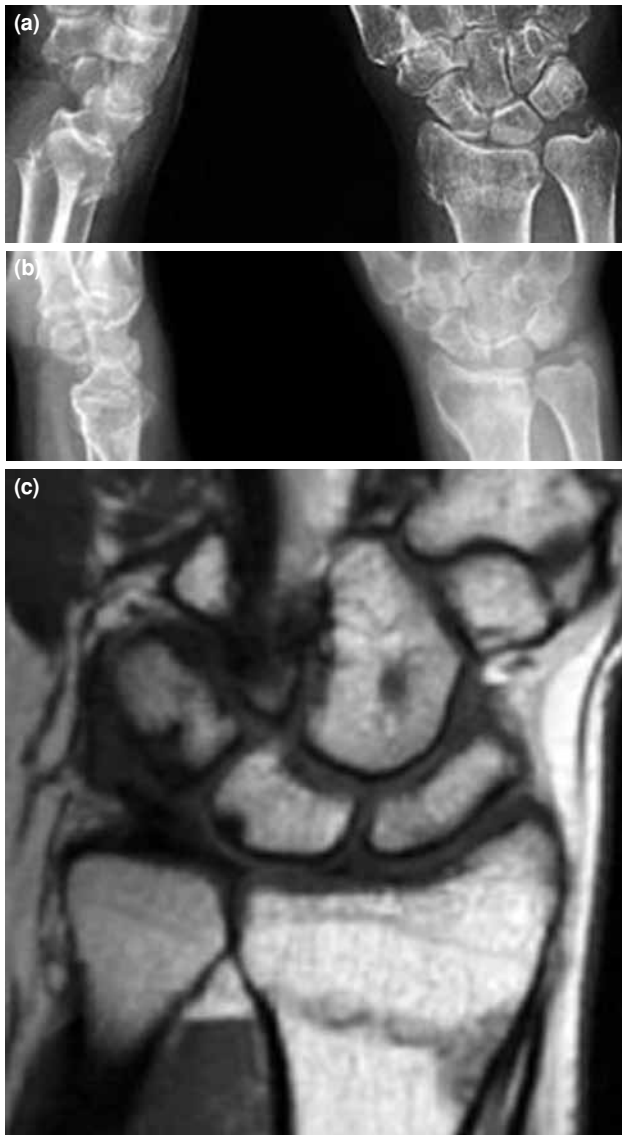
(a) Ulnar impaction syndrome was seen in a 34 year-old male patient after distal radial fracture associated with ulna styloid fracture. Pre-reduction anteroposterior and lateral radiography showed displaced radial fracture. (b) The fracture healed after 16 months and can be seen on anteroposterior and lateral radiography. (c) Cystic changes were seen on lunate and triquetrum bones on T₁-weighted coronal image showing ulnar impaction syndrome.
